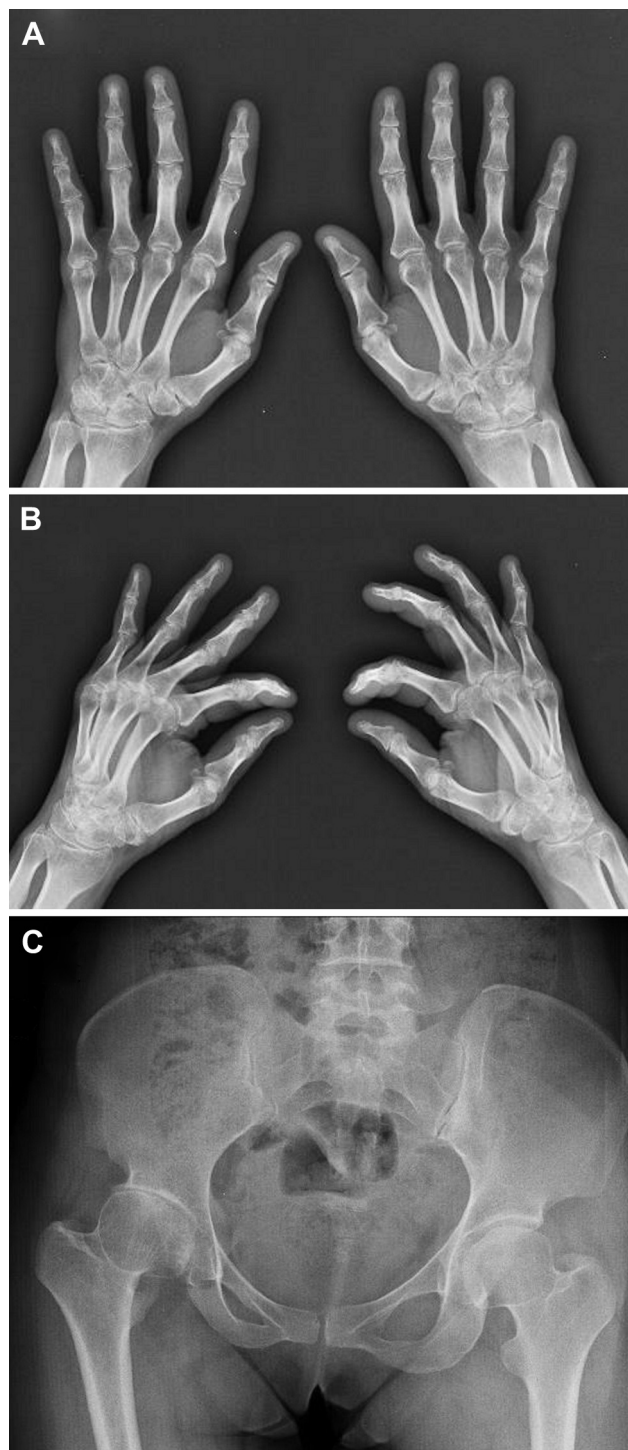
Radiographs of the hands (A, B) show irregularity and sclerosis of the articular surface at the bilateral intercarpal line. A radiograph of the pelvis (C) shows a flattened bilateral femoral head and a narrowed right hip joint. In addition, minimal narrowing of the left sacroiliac joint and increased sclerotic changes in the sacrum and iliac bone are noted.
